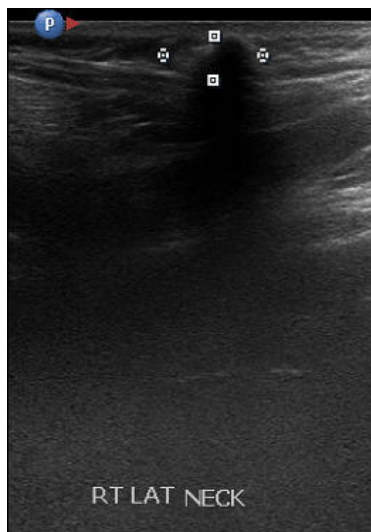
Ultrasound image of the right postauricular region showing superficial echogenic 1.4 x 6.0 mm nodular soft tissue lesion with calcification.
